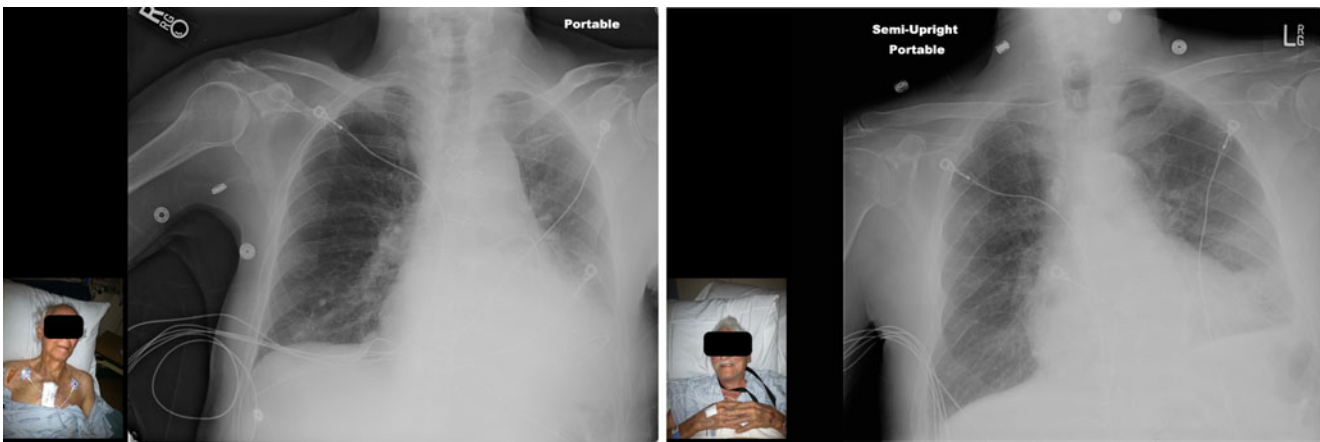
An example display showing a current radiograph–photograph combination (*left*) and a prior radiograph–photograph combination (*right*) from two different patients. For privacy reasons, the patients’ eyes have been masked. Reprinted with permission from the American Journal of Roentgenology [22]
